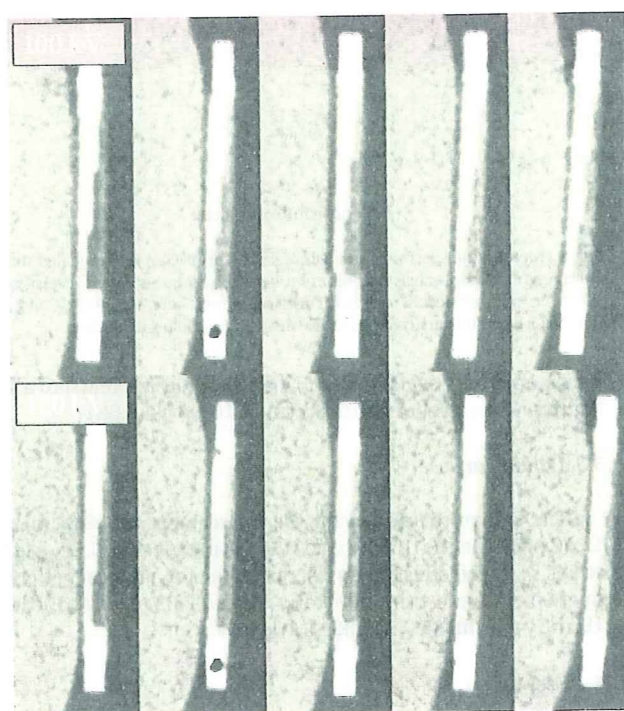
MPR images of soft plaque models. The MPR images of soft plaque models at 100 kV and 120 kV, under intracoronary enhancement of 205 HU and heart rate of 65 bpm, are shown (window level/width: 600/100). All plaques with three stenosis levels are clearly visualized. Note that delineation of plaques is better at 100 kV due to a large difference in CT values between the plaque and intracoronary enhancement.
